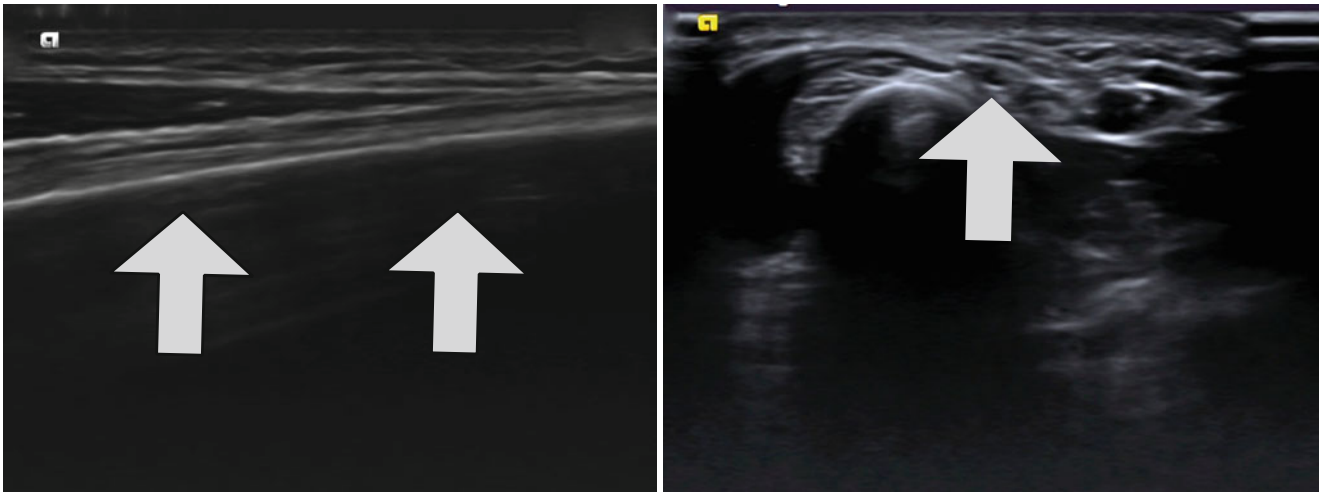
Superficial radial nerve in ultrasound. This image shows the ultrasound finding of a normal radial superficial nerve: (a) longitudinal section and (b) transverse section
